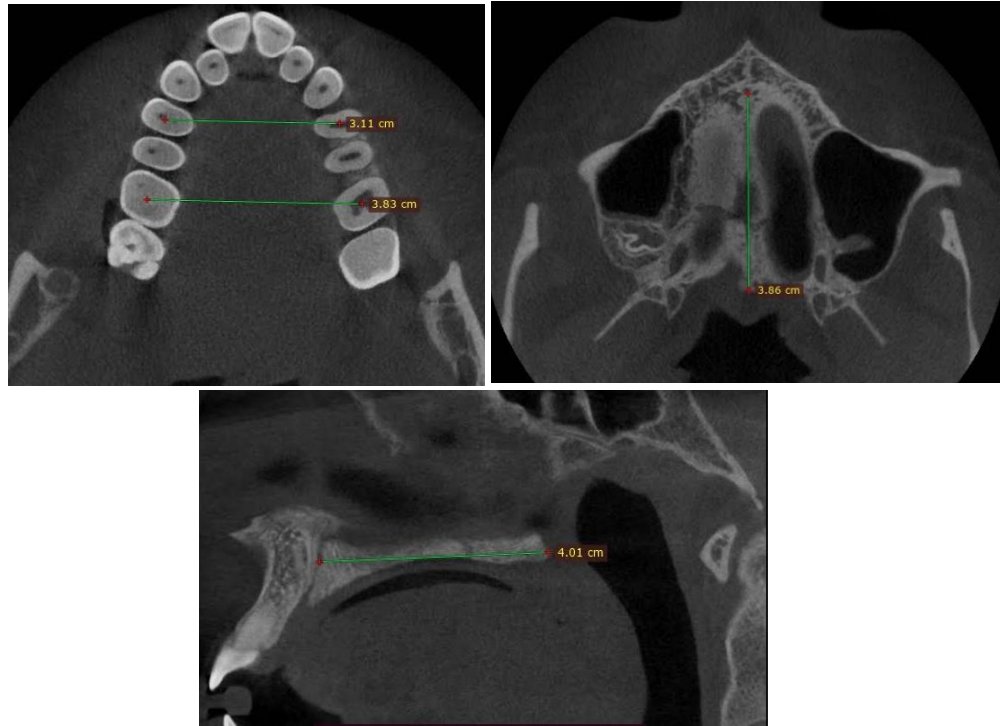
Assessment of midpalatal suture maturation transversely and sagittally after CBCT
